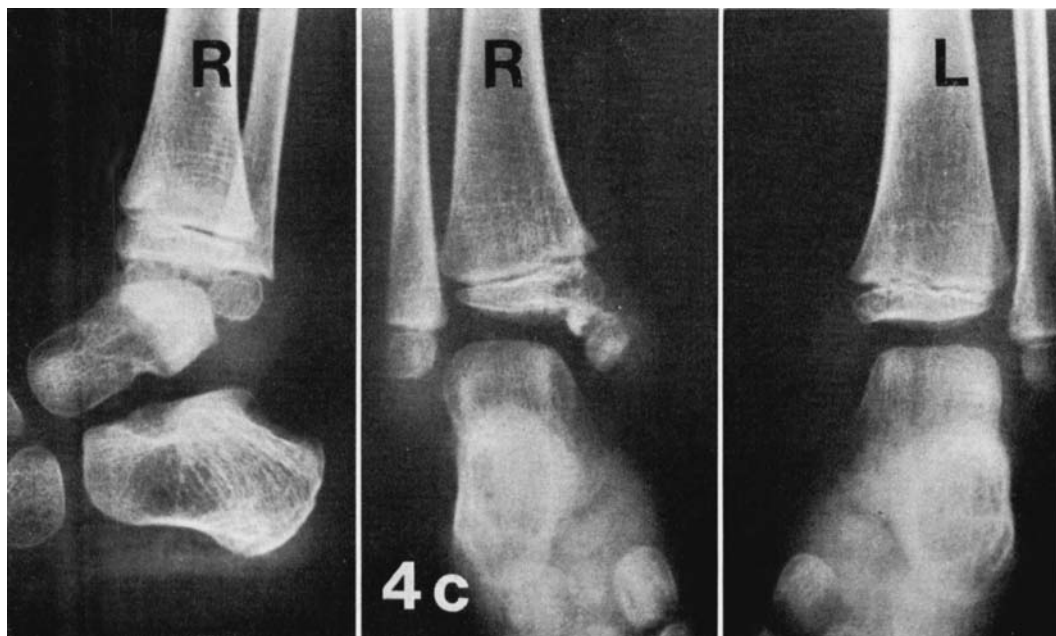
Case 4. a) X-rays of the knee of a boy at the age of 18 months showing enlargement and separated ossification centres in the medial femoral condyle and an exostosis of the tibial metaphysis. b) Pre-operative X-rays at the age of 5 years show a bony tumour fused with the epiphysis. c) X-rays of the ankle at the same age show eccentric ossification centres in the medial malleolus.
